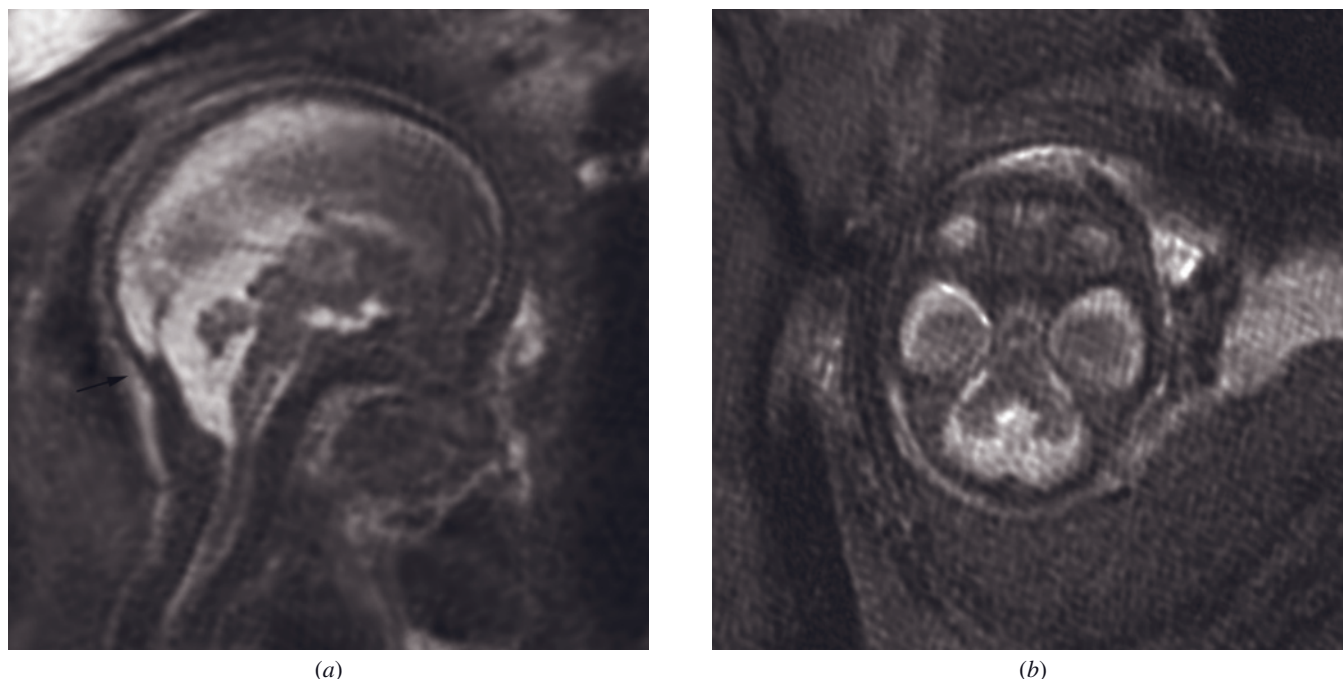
Dandy-Walker variant in two different patients. Sagittal (*a*) and transverse (*b*) T2-weighted SS-ETSE images of fetuses in the second trimester demonstrate a hypoplastic inferior vermis with communication of the fourth ventricle with an enlarged cisterna magna. The posterior fossa is normal in size, with normal position of the torcula Herophili (arrow, *a*).
